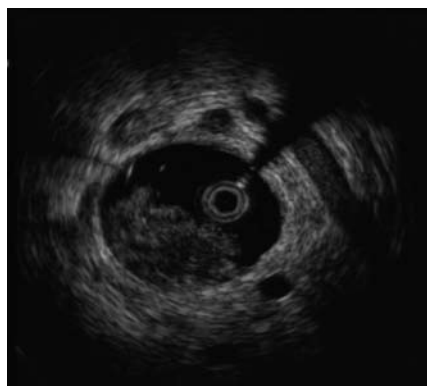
Intraductal ultrasound showing bile duct mass and surrounding lymph nodes.
